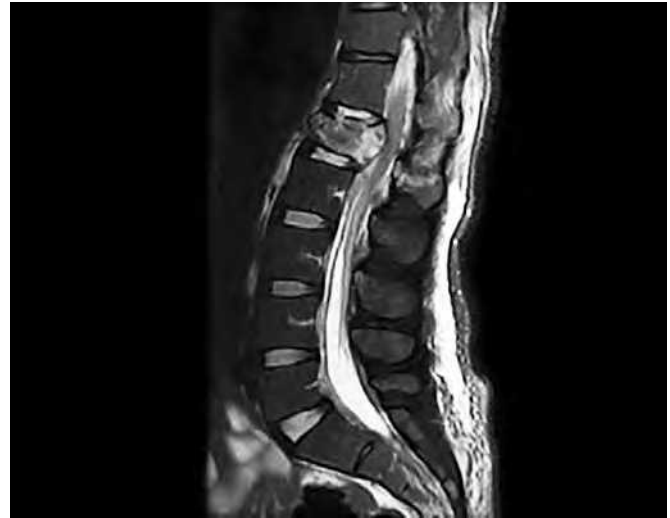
Increased signal in T2-weighted magnetic resonance imaging images at the posterior ligamentous complex represents injury to the posterior stabilizing elements, signifying a more unstable fracture pattern. This injury includes disruption of the supraspinous ligament, ligamentum flavum and the less robust interspinous ligament.
